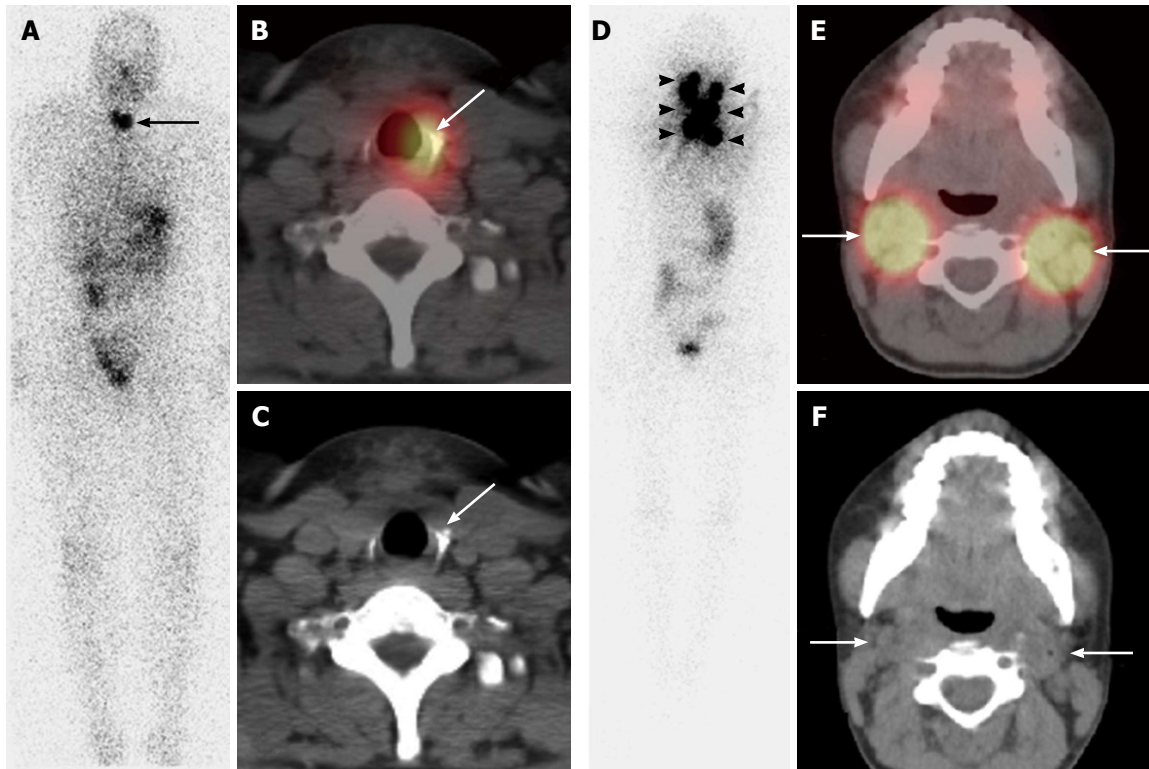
Pre-ablation ^{131}I single photon emission computed tomography/computed tomography scan in a 29-year-old woman with papillary thyroid cancer, the largest lesion measuring 4.2 cm in the right lobe. Post-surgical thyroglobulin was 0.9 ng/mL with a thyrotropin (TSH) of 57 mIU/L. Planar scan (A) depicts two foci of neck activity (long arrow). SPECT/CT (B, C) localized uptake to soft tissue in the left thyroid bed compatible with remnant thyroid tissue (long arrows) and the patient was given a low dose ^{131}I treatment for remnant ablation. Pre-ablation ^{131}I SPECT/CT scan in a 18-year-old woman with multifocal papillary thyroid cancer, the largest lesion measuring 2.0 cm in the left lobe, with capsular invasion; metastatic lymph nodes were resected from the central compartment. Post-surgical thyroglobulin was 223 ng/mL with a TSH of 68 mIU/L. Planar scan (D) depicts multiple foci of neck activity (arrowheads). SPECT/CT (E,F) localized uptake to bilateral bulky iodine-avid lymph nodes in the neck (long arrows), and also the left supraclavicular fossae (not shown). After imaging the patient classified as high risk for recurrence, recommendation was for medium dose ^{131}I therapy. SPECT: Single photon emission computed tomography; CT: Computed tomography.
